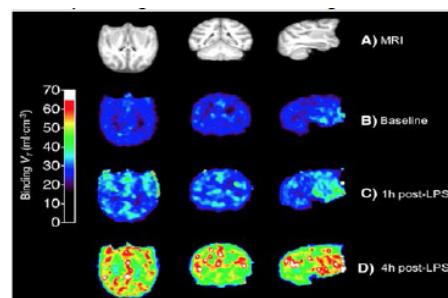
A representative baboon brain. A) MRI of brain. B) This is the baseline image showing sparse inflammation. C) Increased inflammation 1 hour post injection of LPS. D) It reaches a maximum 4 hours post injection.
